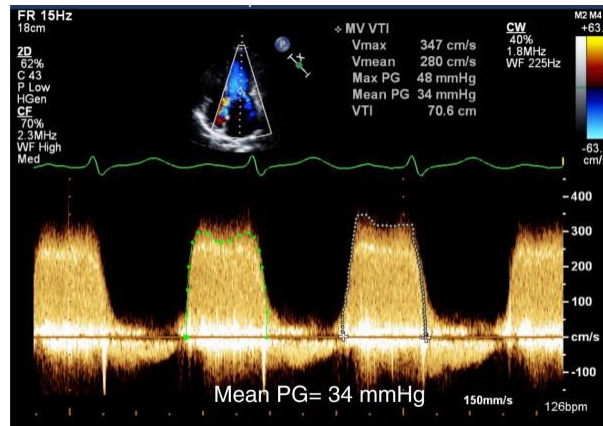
CONTINUOUS WAVE DOPPLER IN MR
